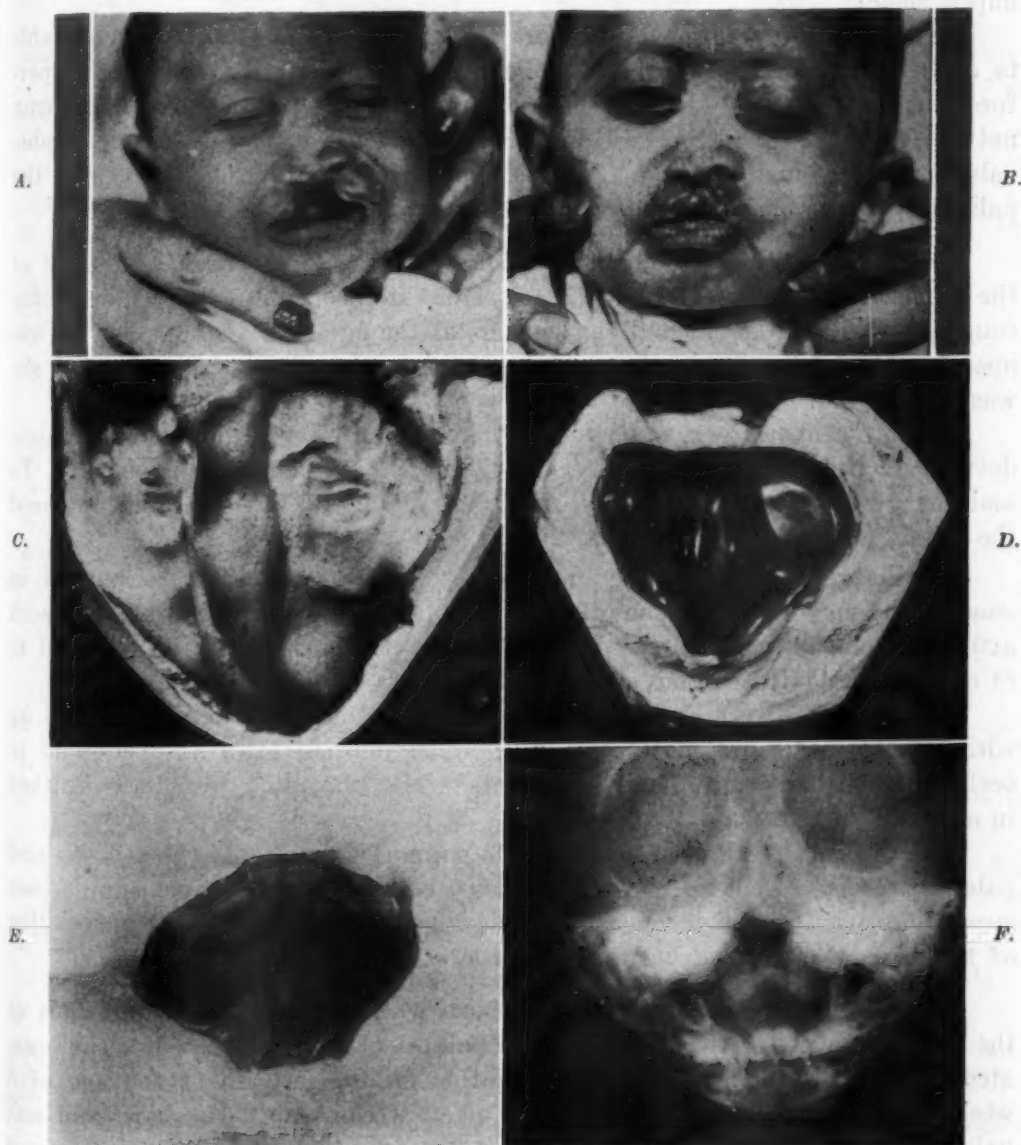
A, Infant with complete cleft of lip, hard and soft palates. Premaxilla congenitally absent. (Courtesy of Roland L. Maier, M.D.) B, Cleft lip repaired. (Courtesy of Roland L. Maier, M.D.) C, Cast of cleft palate. D, Obturator and velum, oral view. E, View of tissue side of appliance. F, Posteroanterior roentgenogram of infant at 9 weeks, confirming absence of premaxilla and revealing developing deciduous teeth.
